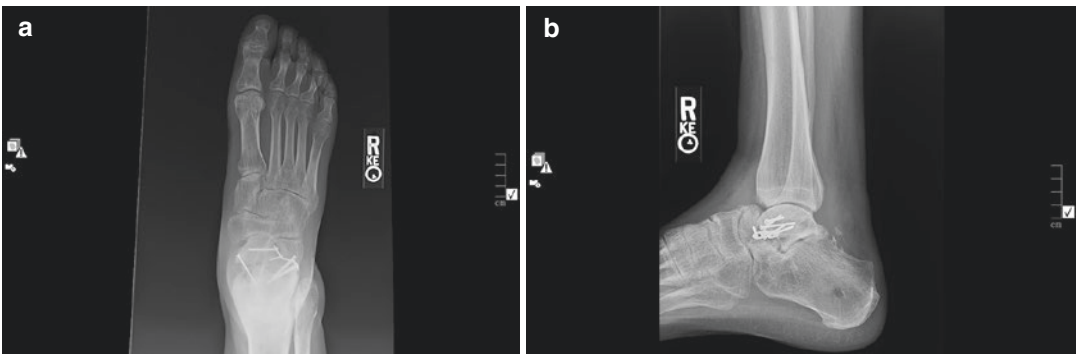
(a, b) Final X-rays on follow-up demonstrate union with marked shortening of the talar neck at 3 years. The patient, however, is surprisingly ambulating without pain and only has mild residual stiffness. There is no
